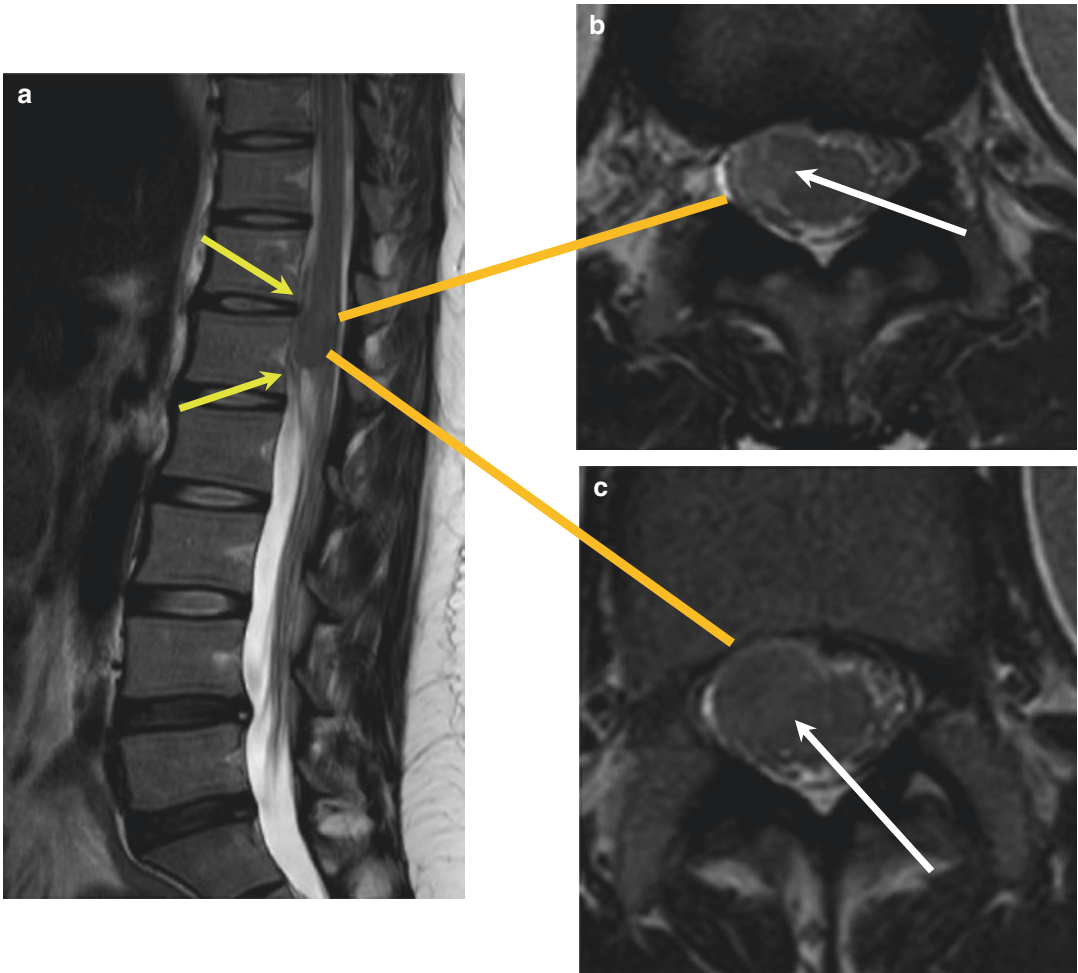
Exophytic intramedullary tumor at the conus medullaris in a 46-year-old female. (a) On the sagittal T2-weighted image, the tumor mimics appearance of an intradural extramedullary tumor with cord compression
